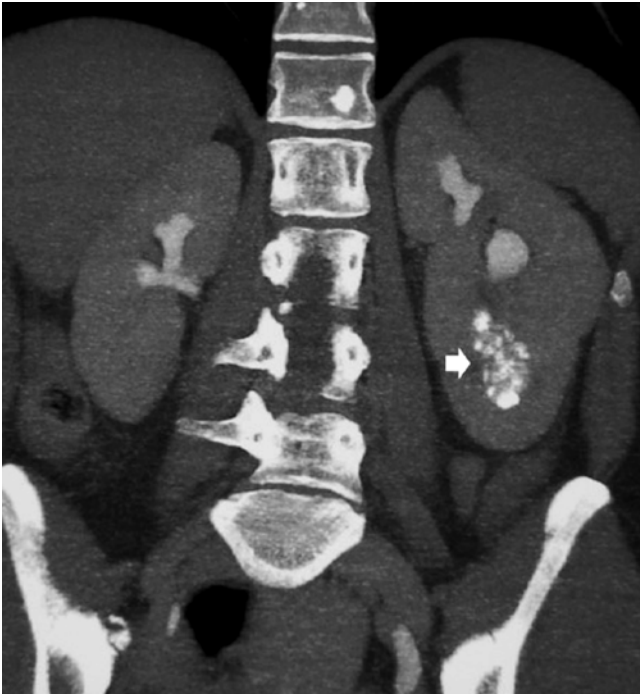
CT urography. Coronal reformats. Renal sponge kidney with regional medullary nephrocalcinosis (*arrow*) (From the editor E. Quaia)
